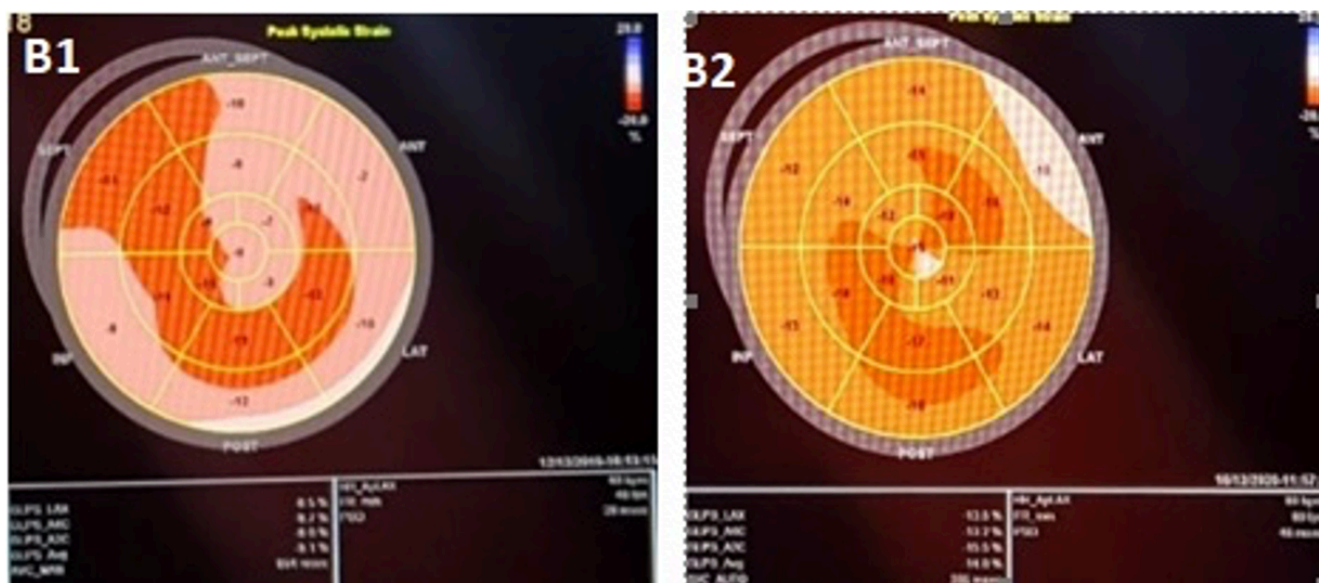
2D Speckle strain echocardiography finding B1: at admission, B2: 6 months of follow-up
